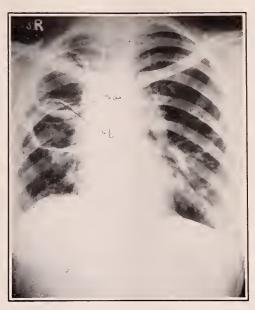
Case XVI. Roentgenogram of June, 1930, showing very large double cavity (a), (b), occupying most of upper two thirds of right lung.
